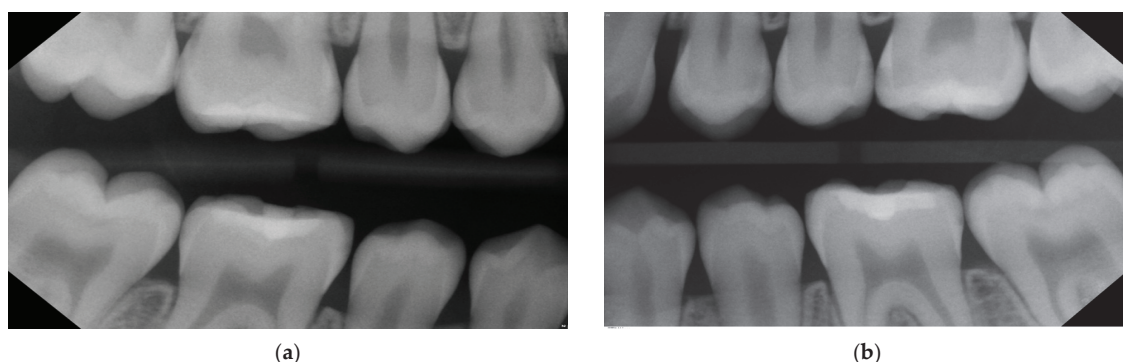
Case 2—Baseline: bitewings in 2019 show the proximal non-cavitated lesions on the right (a) and the left side (b) at the age of 13. Only non-invasive caries management options including regular recall and fluoride varnish application were undertaken at this point. For a lesion assessment, see Table 2.
